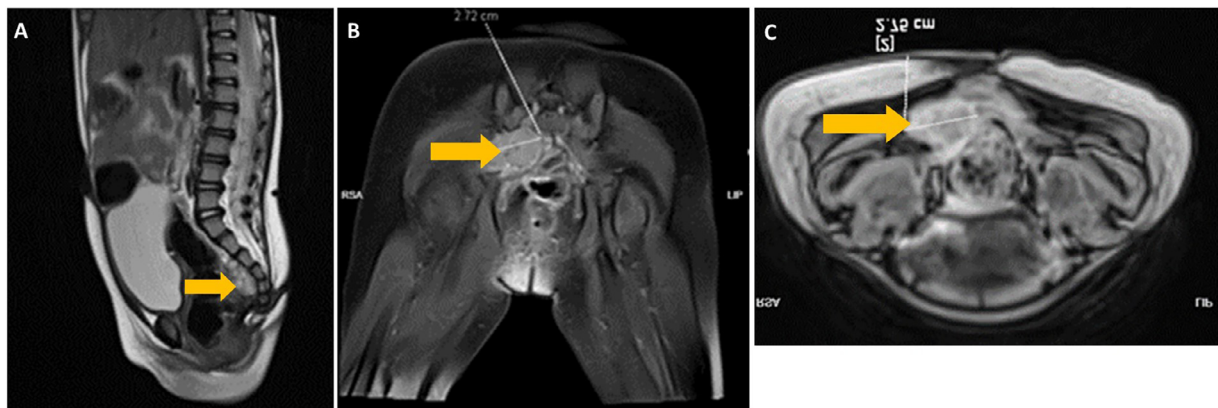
MRI pelvis showing sacrococcygeal tumor measuring 2.75 x 2.3 x 2.72 cm in size (yellow). It was infiltrating the right sacral nerve root, protruding into the right greater sciatic foramen, abutting adjacent recto-sigmoid reflection and gluteus muscles.
